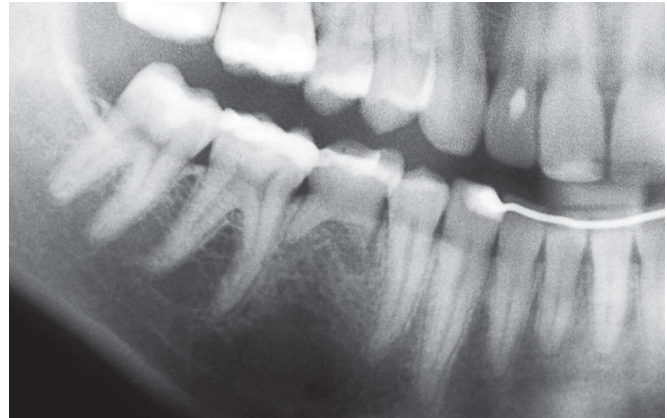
Radiographic appearance of deciduous tooth and underlying bone.
